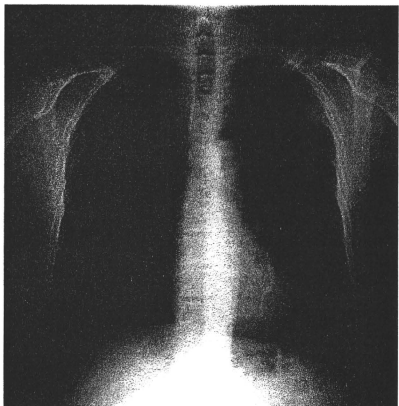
Chest X-ray image obtained 17 months after gastrectomy showing a nodule (29 mm) in the left upper lung field.
